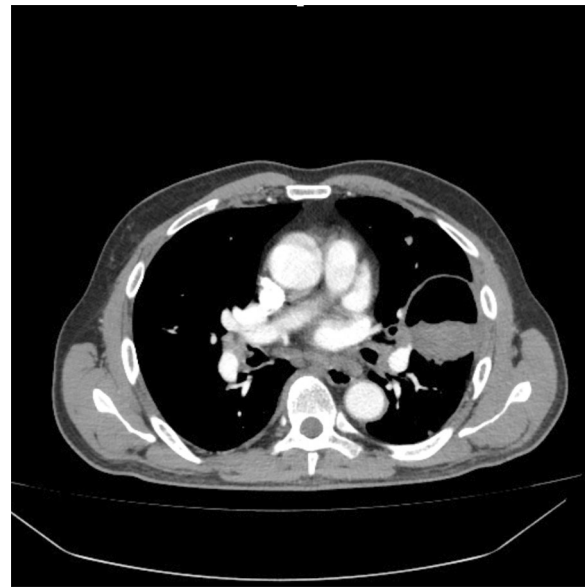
CT scan showing a 75×80 mm thin margin cavity in the upper lobe of the left lung with multiple folding membranes in its dependent portion in a patient with positive ELISA IgG CE
